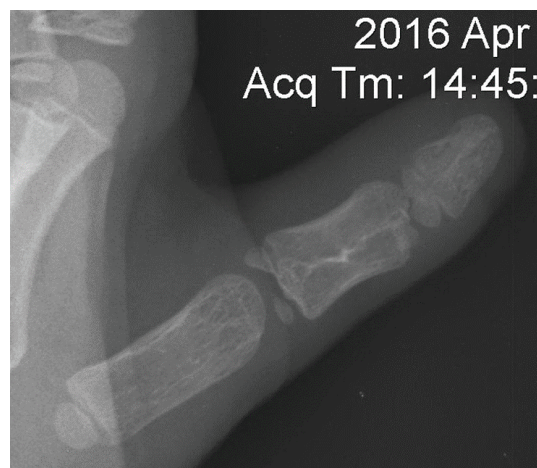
X-ray examination after two-stage modification of Bilhaut-Cloquet procedure (follow up 5-years).
